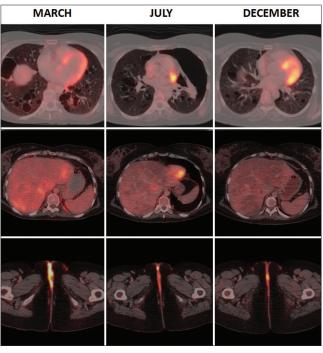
Positron emission tomography-computed tomography scan images of March (Column 1) show mildly fluorodeoxyglucose avid nonfluorodeoxyglucose avid thick walled cystic lesions in bilateral lungs, multiple fluorodeoxyglucose avid hypodense lesions in liver and fluorodeoxyglucose avid thickening in perianal and vulvar regions. Positron emission tomography-computed tomography images of July and December (Column 2 & 3) show complete response in lung lesions, moderate response in liver lesions, and mild response in perianal and vulvar lesions
